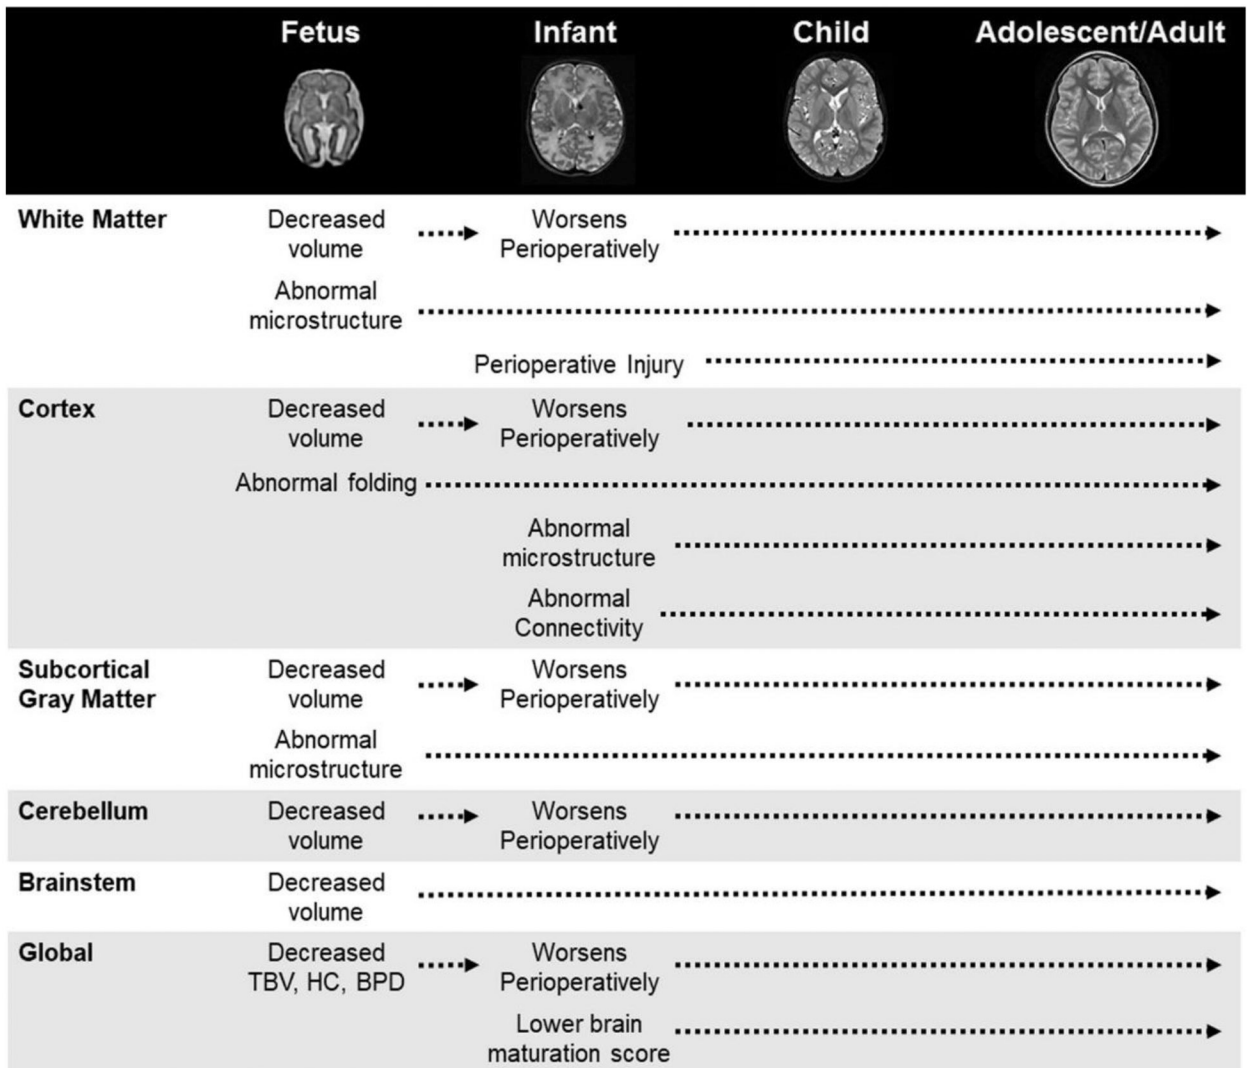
Timing and Pattern of Neuroimaging Abnormalities. This timeline depicts abnormalities identified across key brain regions in neuroimaging studies of brain development in patients with CHD, beginning during the fetal period and extending into adolescence/adulthood. Representative T2-weighted images are provided for each developmental epoch depicting the significant change in brain size and structure that occurs during this period. As demonstrated, brain abnormalities in CHD are global in nature, involving white and gray matter regions at the micro- and macro-structural level. BPD, biparietal diameter; HC, head circumference; TBV, total brain volume.
